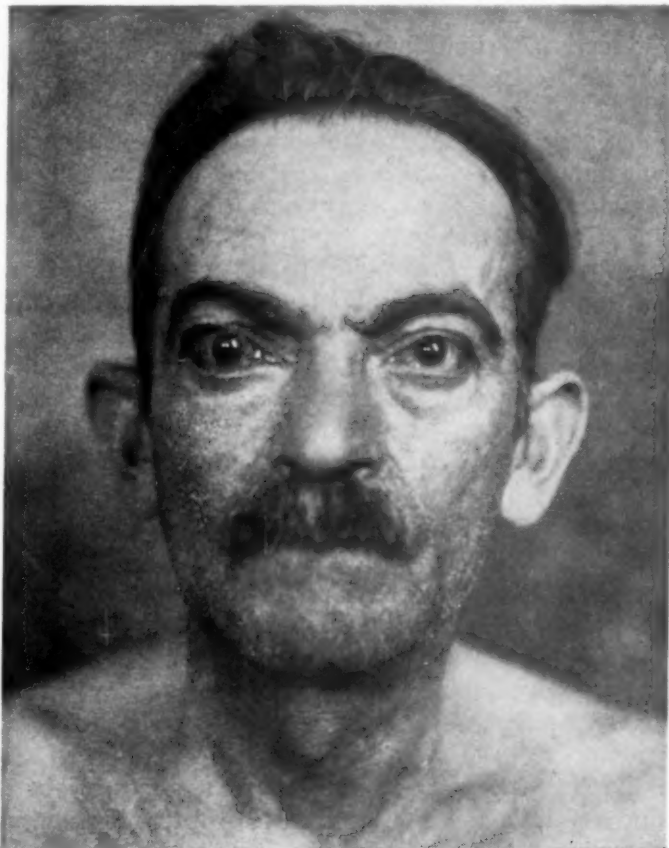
Regression of exophthalmos following roentgen therapy to orbital and pituitary regions (June 18, 1937).
